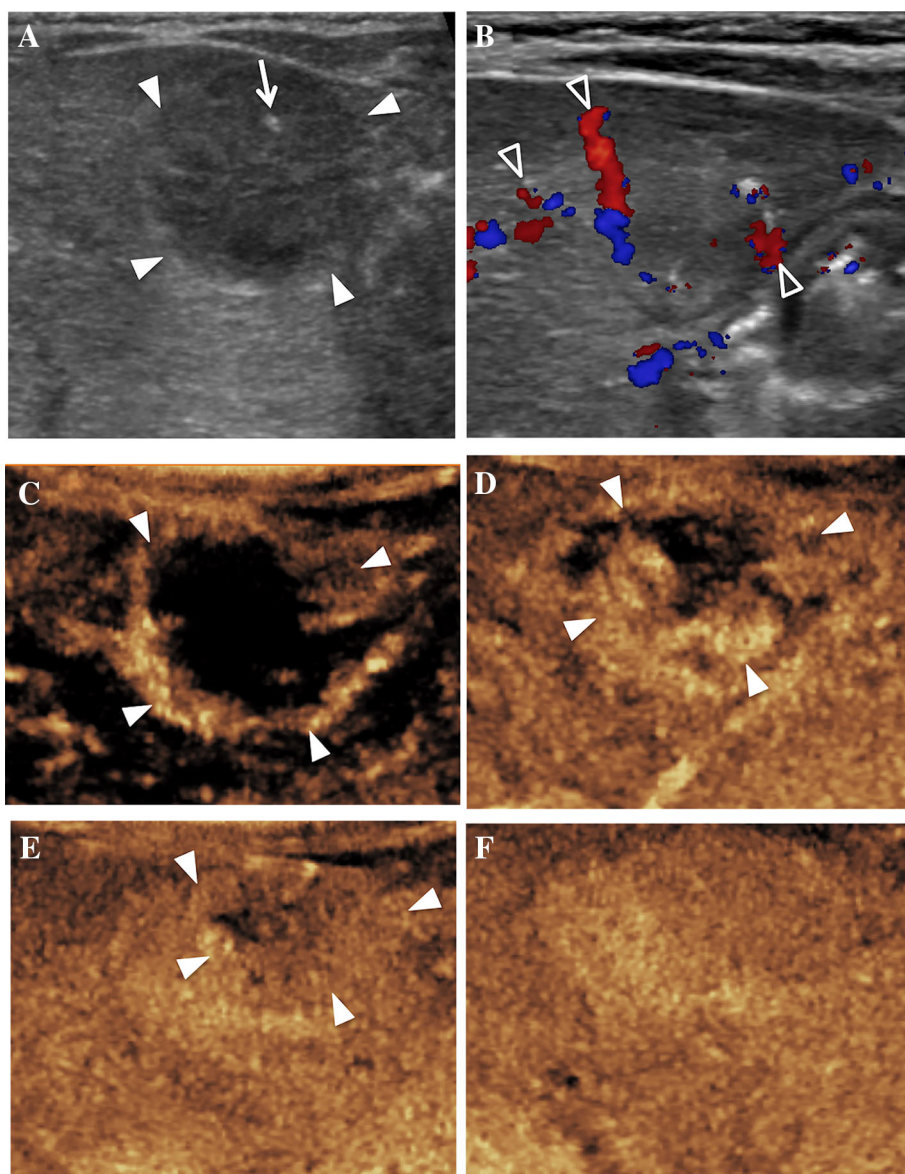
IV CEUS. Solitary infantile hepatic hemangioma. 2-month-old boy presents with vomiting and abdominal pain. Ultrasound was requested to rule out pyloric stenosis. A Baseline gray scale ultrasound. Incidental note is made of a 2 cm in maximum diameter, spherical, predominantly hypoechoic, solid lesion (solid arrowheads) in the anterior left hepatic lobe with presence of an internal hyperechoic focus consistent with calcification (arrow). B Color Doppler shows several vessels around the periphery of the lesion (open arrowheads) with a few vessels extending into the lesion. C--F Contrast-enhanced Ultrasound. Following intravenous injection of the ultrasound contrast agent, there is early peripheral nodular enhancement of the lesion (arrowheads) with progressive centripetal filling and complete-homogenous enhancement in the delayed phase. These findings are consistent with infantile hepatic hemangioma. No other investigation performed.
